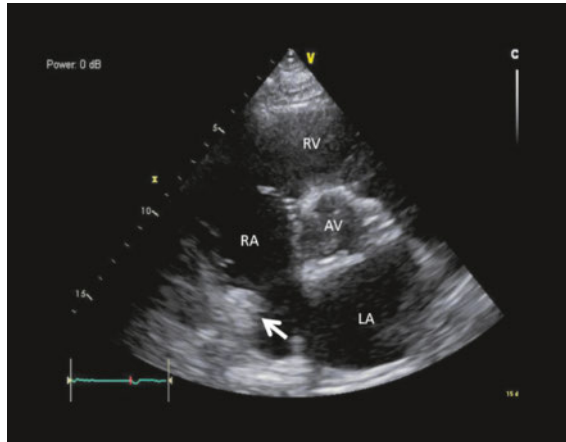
Transthoracic echocardiography parasternal short-axis view: white arrow point to thrombus in the right atrium.
